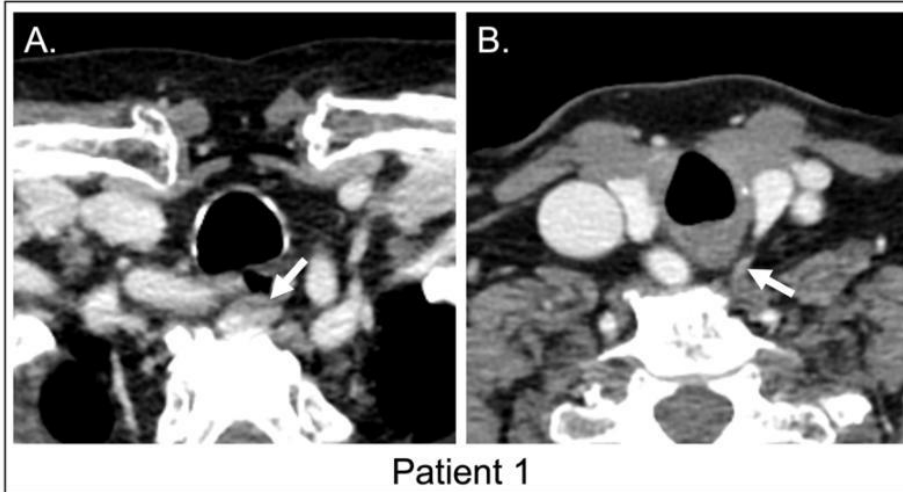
Axial contrast-enhanced CT images obtained in 2 different PHPT patients undergoing pre-operative parathyroid CT. In patient 1, two high-confidence candidate lesions are identified – a large retroesophageal lesion (arrow, A) and a smaller lesion along the posterior aspect of the left thyroid lobe (arrow, B). The EV and MD of both lesions were greater than 60 mm^3 and 7 mm, respectively, and both lesions required removal at surgery for the desired biochemical result (i.e., MGD). In patient 2, a single high-confidence candidate lesion (arrow, C) was identified (i.e., no second lesion with $\text{EV} \geq 60 \text{ mm}^3$ or $\text{MD} \geq 7 \text{ mm}$). Despite this single lesion's small size, which would favor MGD according to an earlier predictive model (2, 3), the desired biochemical result was achieved after the removal of this single lesion (i.e., SGD).
